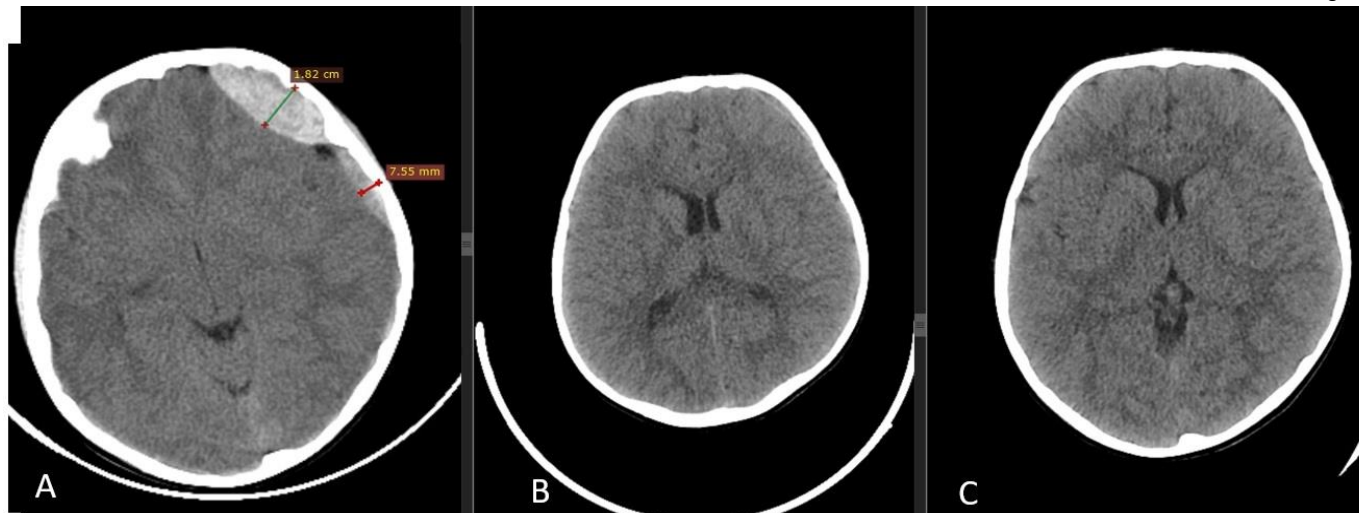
A 5-year-old male patient (Patient 20, table 1) was brought to the emergency department after a fall from a height of 2 meters. Axial CT scan shows a left frontal 18mm and temporal 7mm in thickness multilobar PEDH (A). Axial CT scan of the same patient taken 3 months after discharge demonstrated marked resolution of the EDH. But, some residual dural calcification was observed (B). Axial CT scan of the same patient taken 6 months after discharge showed that total resorbed (C).
